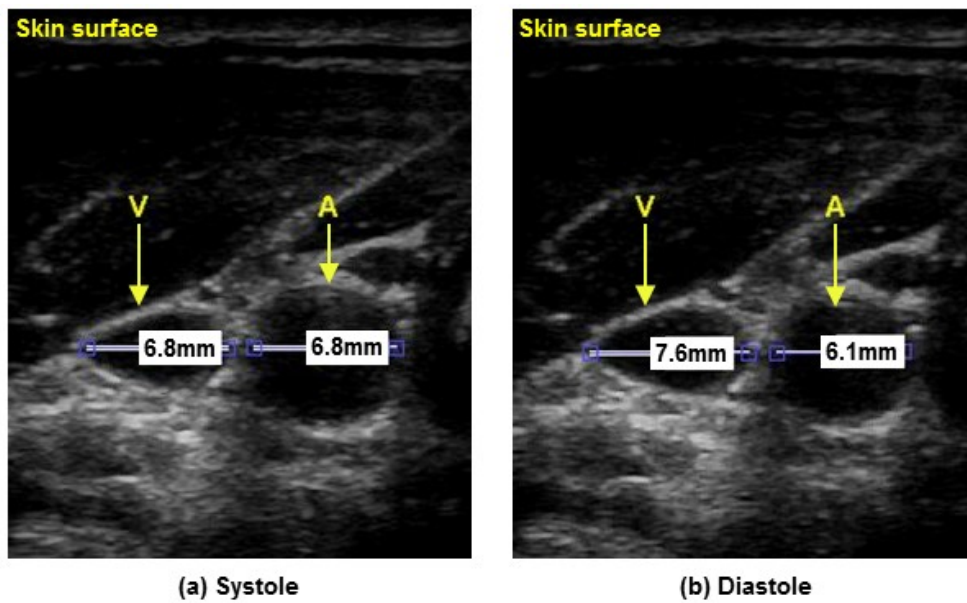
Inverse relationship between the carotid artery and jugular vein as seen with B-mode ultrasound in a typical participant. The jugular vein (below V) and carotid artery (below A) are located below the skin surface (top) with vessel diameters marked in millimetres. Between systole (a) and diastole (b), the carotid relaxes (10% diameter reduction), and the jugular expands (12% diameter expansion).
